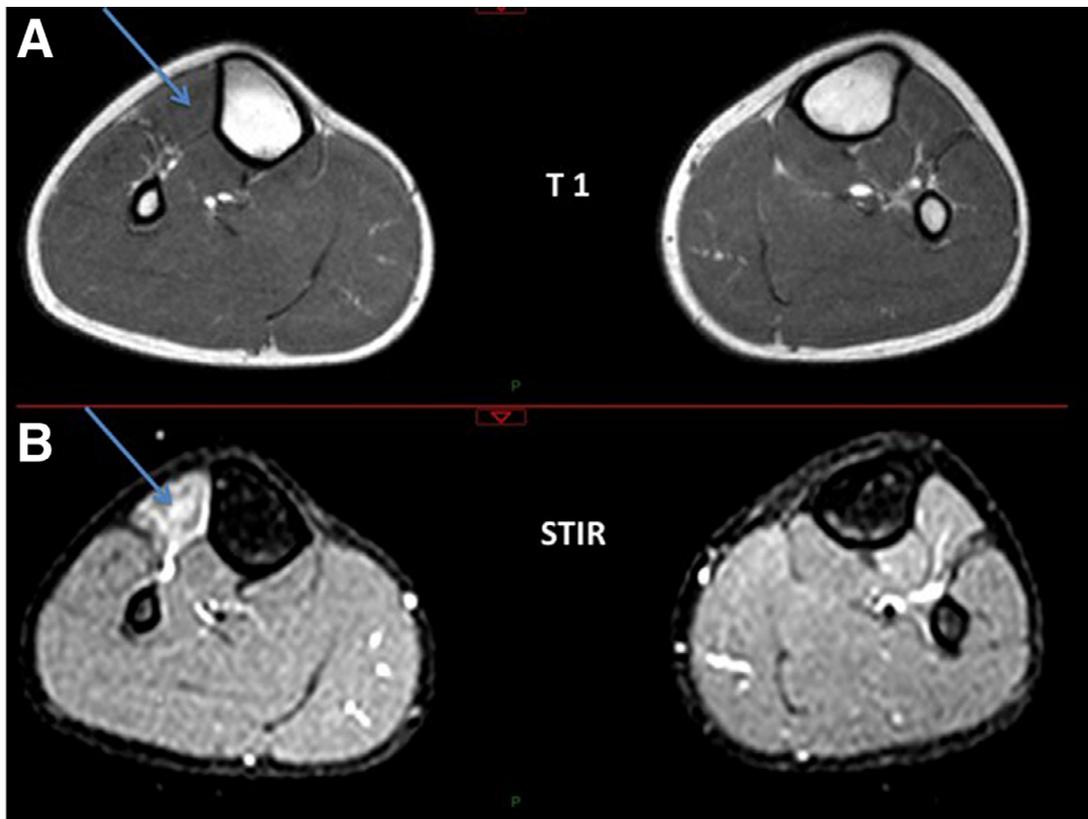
demonstrates lower leg MRI images obtained in 2 standard sequences in early stage of FSHD. Typical images obtained in 2 separate sequences not simultaneously acquired, T1 usually can demonstrate fat replacement and dystrophic changes, and is normal in Fig. 1A. Fig. 1B demonstrates that the right tibialis anterior is hyperintense reflecting increase water content/edema indicating early myopathic changes.
